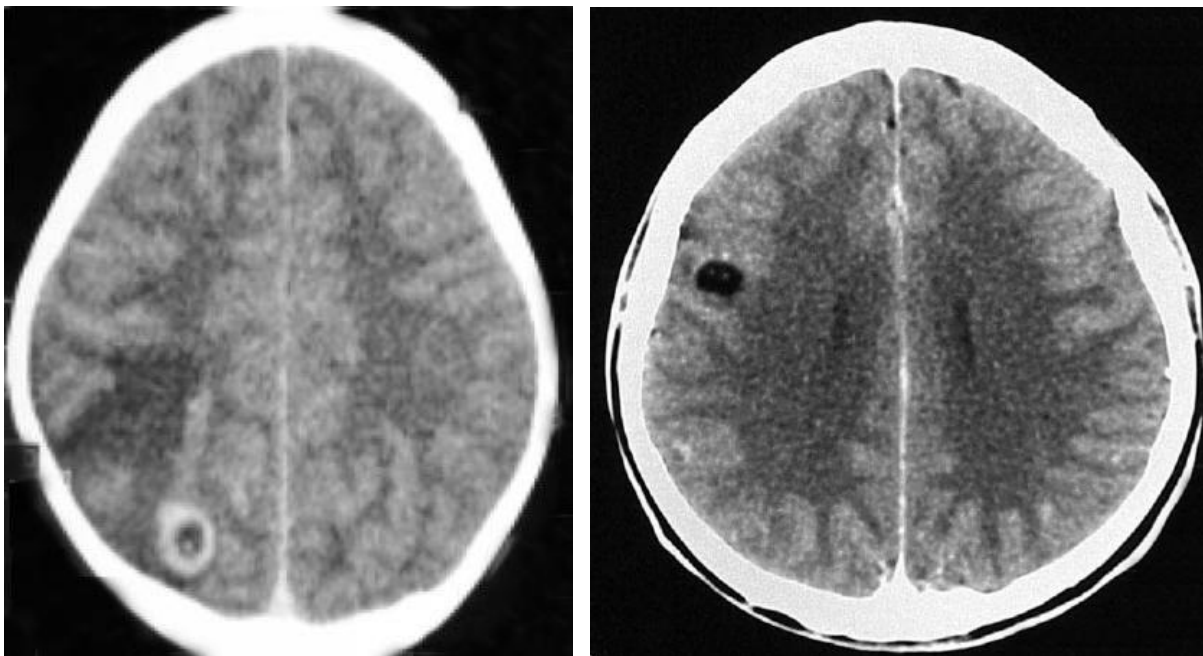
Single nodular ring enhancing lesion on Contrast enhanced CT scan (Central dot represents scolex)
